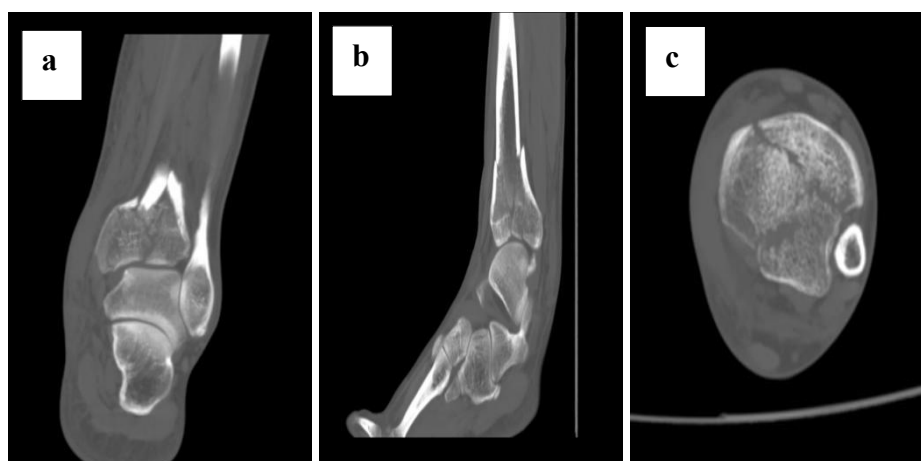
Preoperative CT imaging data. a The sagittal CT view reveals a distal tibial fracture involving the articular surface; b The coronal CT view shows a fracture of the distal tibial articular surface; c The axial CT section indicates a comminuted fracture of the distal tibial articular surface
